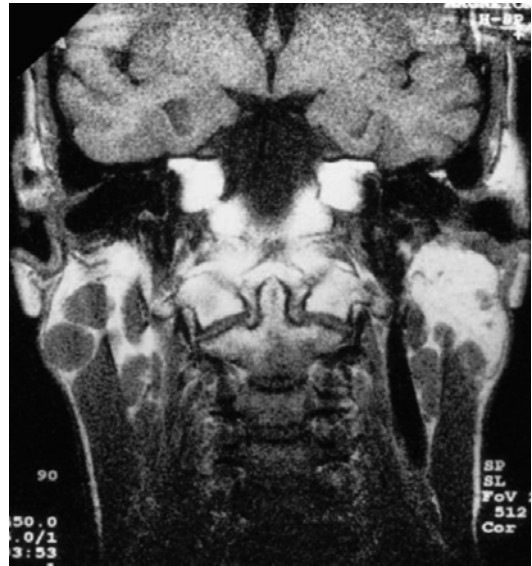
MRI showing the characteristic Swiss cheese appearance of multiple large cystic lesions
